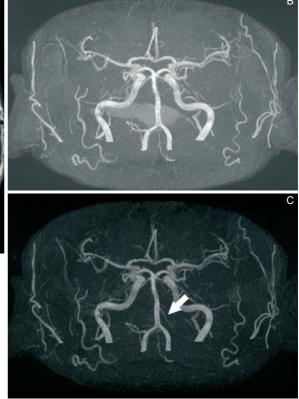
Intra-axial cerebellar haematoma. The lesion is hyperintense in T1-weighted image (A) due to extracellular methemoglobin; in conventional MRA (B) this tissue mimics flow signal, while in subtractive MRA (C) background signal is completely removed and left anterior-inferior cerebellar artery (arrow) is displayed. In this patients digital subtraction angiography examination don't show any vascular malformations.
